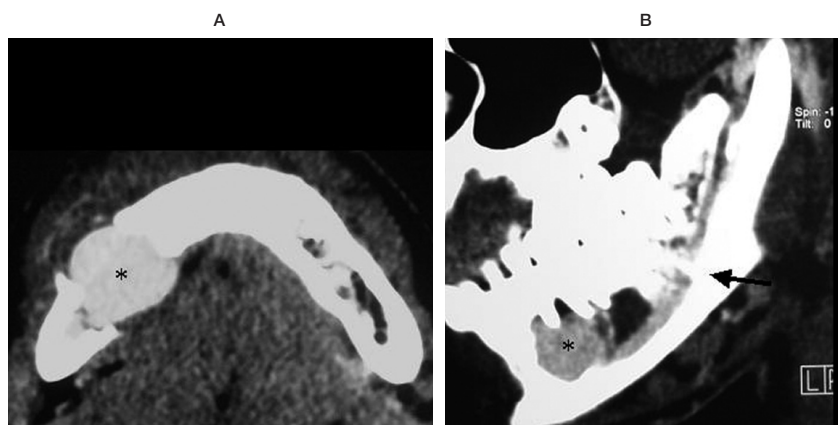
CT angiography axial (A) and parasagittal (B) images. Aneurysmal dilatation of a vessel is visible within the mandibular bone lesion (asterisks). An enlarged inferior alveolar artery and vein are also visible within the mandibular channel (arrow).
